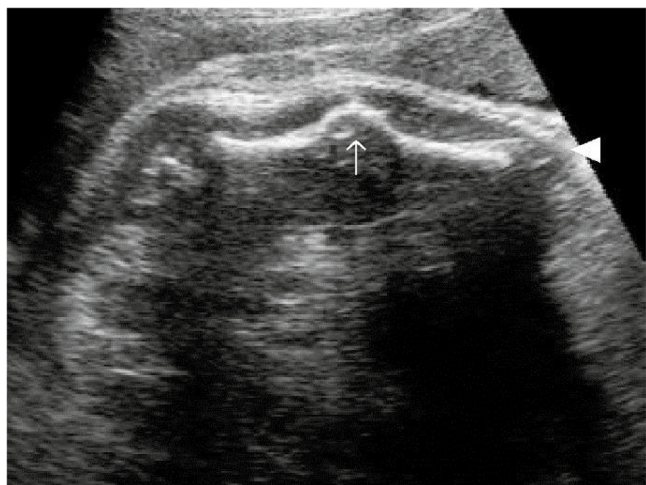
Congenital syphilis showing an affected fetal bone. Courtesy of Bailão et al. *Ultrasound markers of fetal infections Part 2. Ultrasound Quarterly* 2006;22:137-151.
